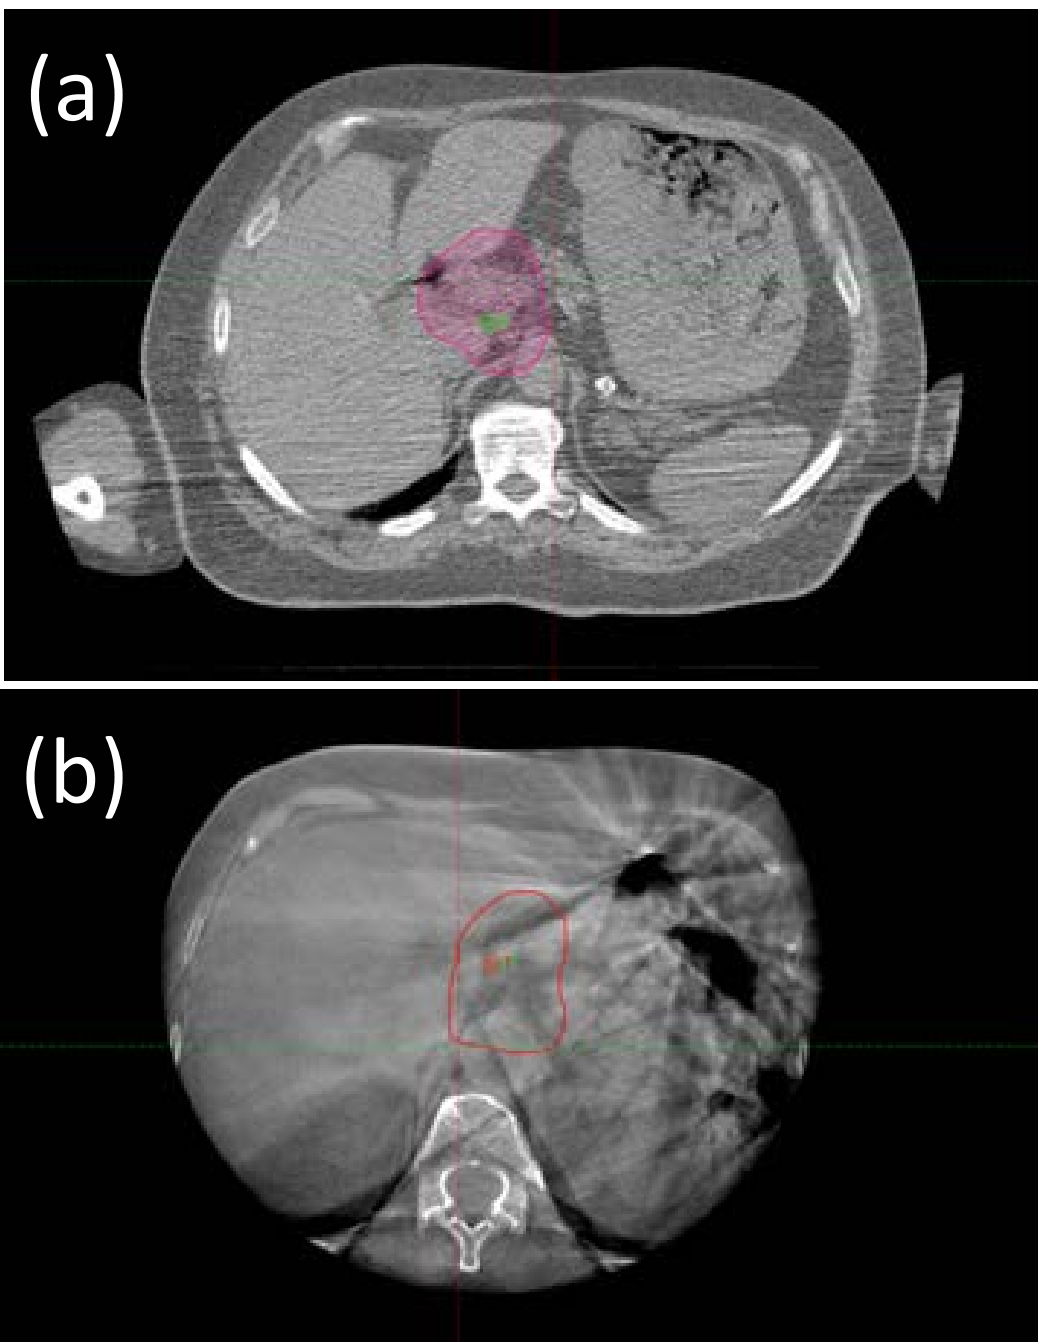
Examples of abdominal imaging using (a) RefleXion fan beam kVCT and (b) C-arm CBCT
